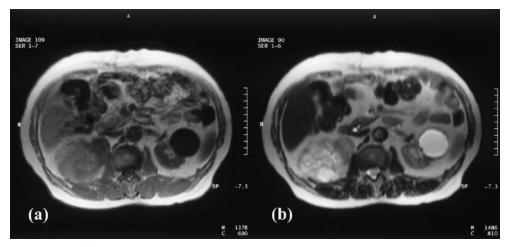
(a) On MRI examination, T1-weighted axial image view demonstrated a right renal mass that was hyper-intense relative to the renal parenchyma. (b) T2-weighted axial image view demonstrated a right hyper-intense mass with thickened septa (>1 mm).
